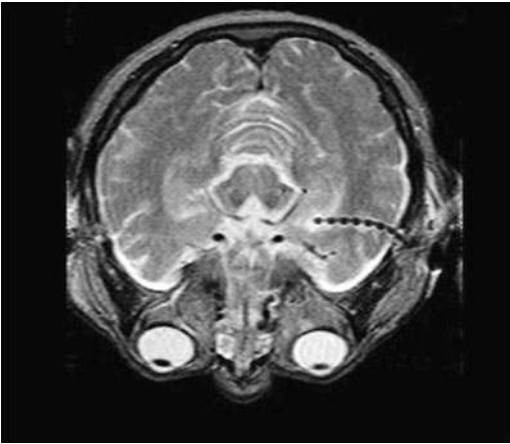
MRI scan highlighting left temporal depth lead placement used in recording the ictal activity depicted in Figure 15-3. (Note: Depth leads in the opposite temporal lobes and bilateral frontal lobes are not depicted in this image).
